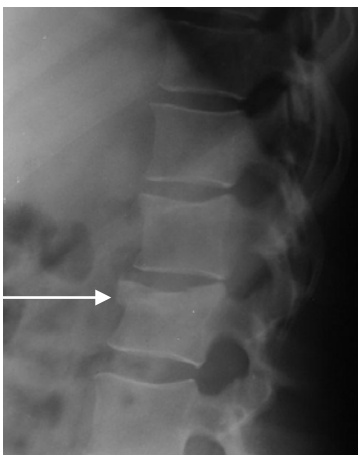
The radiograph of lumbar department of the backbone in a lateral projection. Vertebra displacement is absent. Anterior compression of the body of the third lumbar vertebra is detected (arrow)
